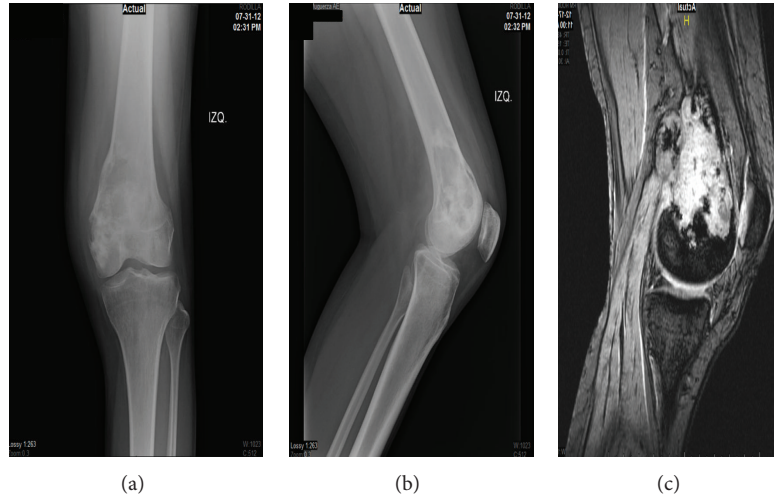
((a) and (b)) Permeative pattern in distal femur; (c) malignant looking lesion is corroborated with a MRI. MRI: magnetic resonance imaging.
